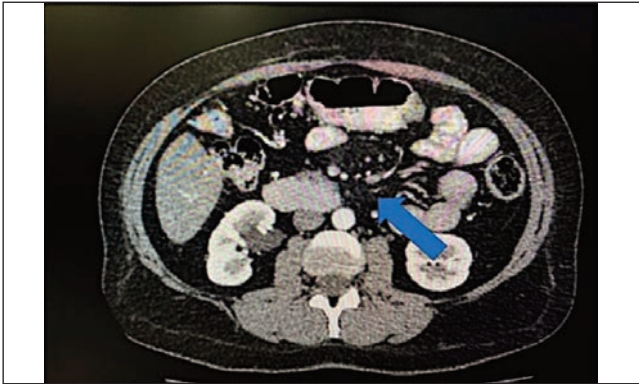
CT scan of the abdomen with contrast axial view of Case no. 3 showing an area of increased density of mesenteric fat at the root of mesentery which appeared misty with small mesenteric lymph nodes within it.
